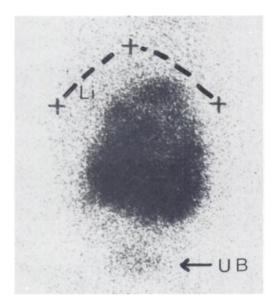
Anterior I-131 MIBG scintigram of neuroblastoma, made at 143 hr after injection. Li = liver, UB = urinary bladder.
